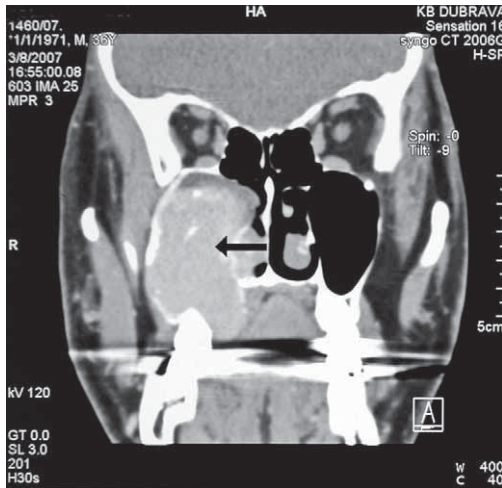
CT-scan showing tumor mass in the right maxillar sinus (frontal view).
